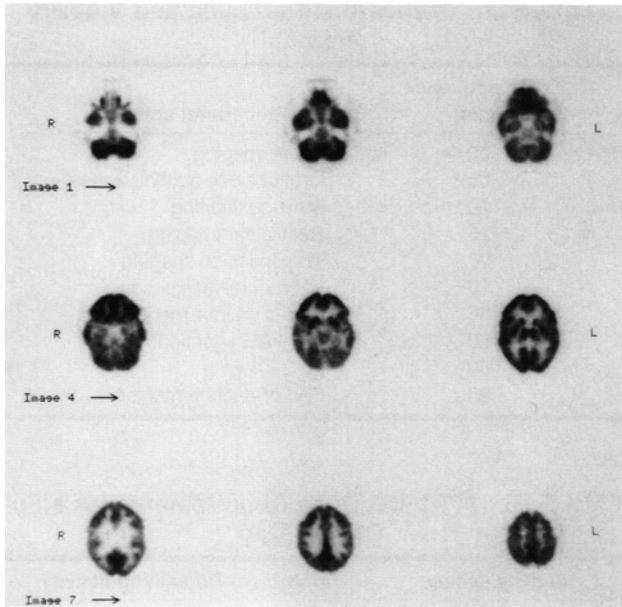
Normal FDG brain metabolism images.
